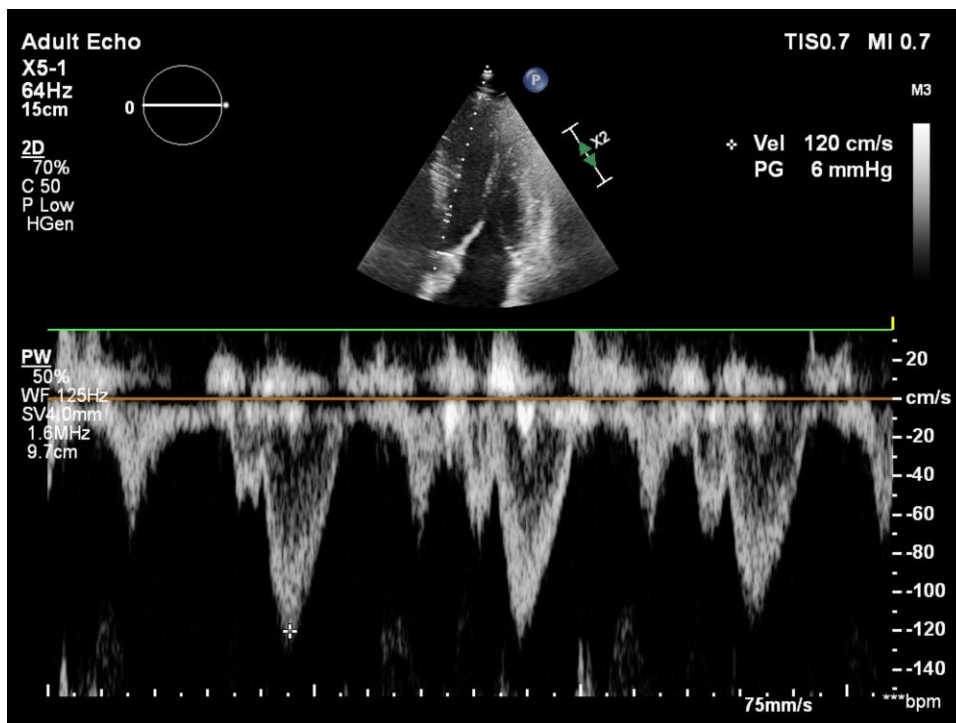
Transthoracic echocardiography—post-procedural maximum left ventricular outflow tract gradient.
